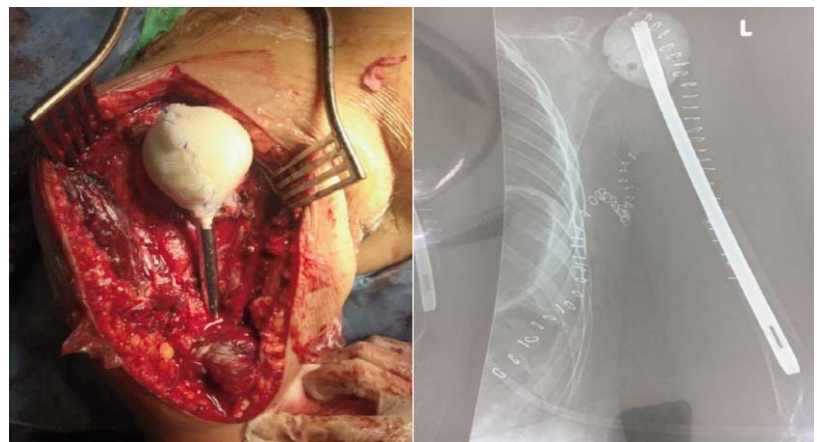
Clinical photograph and post op radiograph of a nail cement spacer in situ after tumour extirpation, with a prolene mesh used to stabilise the implant at the joint due to deficiency of rotator cuff and deltoid muscles.
